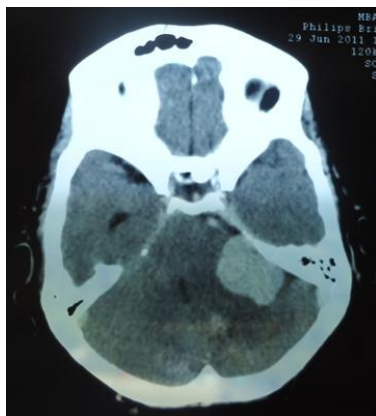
CT image of meningioma of left cerebellopontine angle
